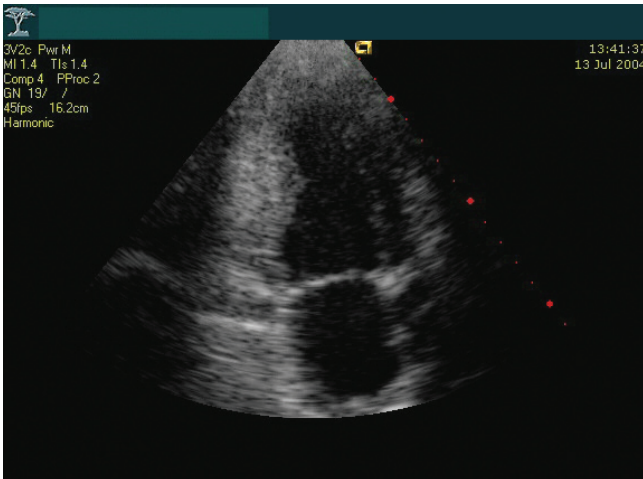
Parasternal long axis image of the left ventricle and left atrium demonstrating mild left ventricular systolic impairment with normal antero-septal regional wall motion and posterior hypokinesia
